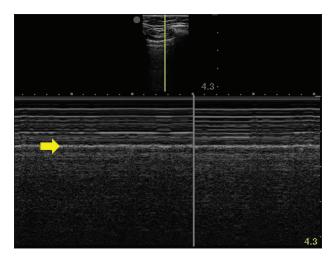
Point-of-care ultrasound showing the seashore sign. The pleural line is marked (yellow arrowhead). Above the pleural line, the motionless soft tissue creates horizontal or stratified lines. Below the pleural line, the sliding lung creates a granular pattern, the sand or seashore
